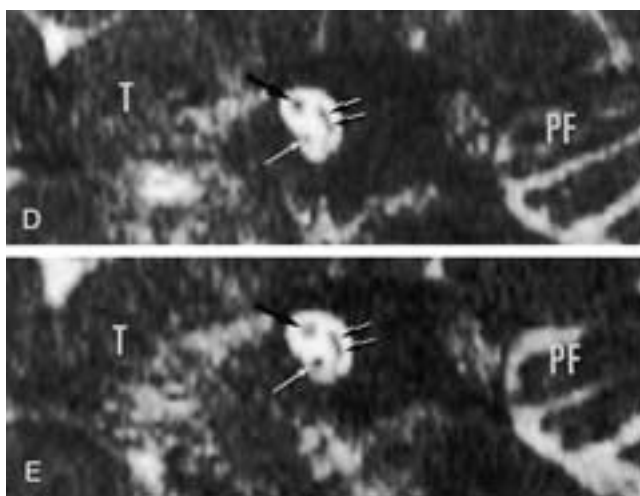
Continued.* D, Gradient-echo T2-weighted parasagittal reconstructed image through the lateral part of the left internal auditory canal. On this 3DFT-CISS image the facial nerve (*large black arrow*) has a much larger diameter than the cochlear branch of the VCN (*long white arrow*). The common vestibular branch of the eighth nerve has a normal size (*small black arrows*). E, Gradient-echo T2-weighted parasagittal reconstructed image through the lateral part of the normal right IAC for comparison. The facial nerve (*large black arrow*) and cochlear branch of the VCN (*long white arrow*) have a similar diameter, which is a normal finding. The common vestibular branch of the VCN is normal in size (*small black arrows*). PF, posterior fossa; T, temporal lobe.
